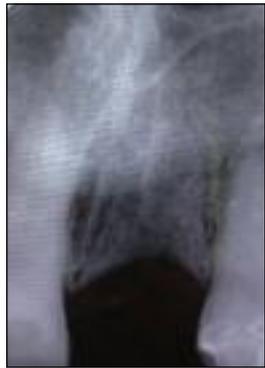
The peri-apical radiograph showing the area of bone at the UL1 site at the pre-operative
